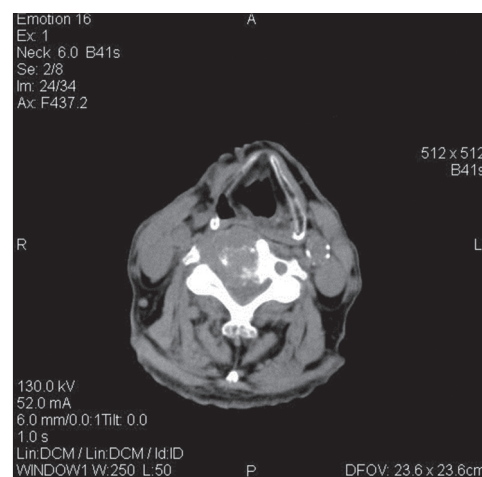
CT scan image of the neck shows a mass in the right thyroid lobe causing severe destruction of the adjacent vertebrae and extending into the vertebral canal. CT = Computed tomography
